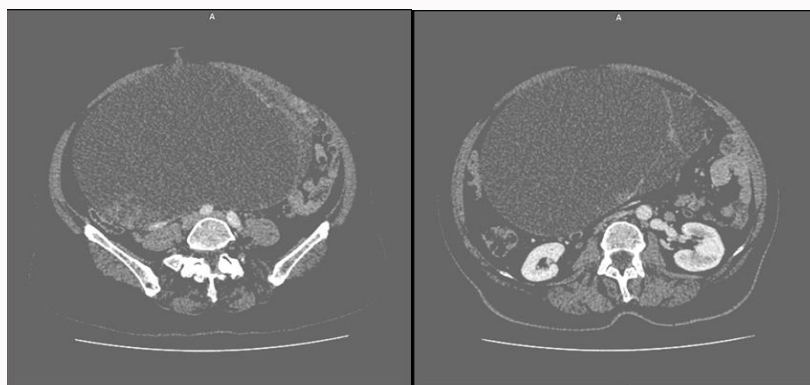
CT images of the patient.
